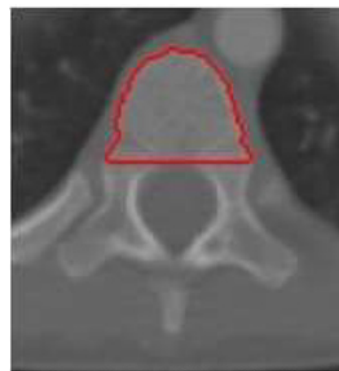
CT scan of T10 of a 4-year-old subject. The ROI for evaluating BMD is shown in red.
